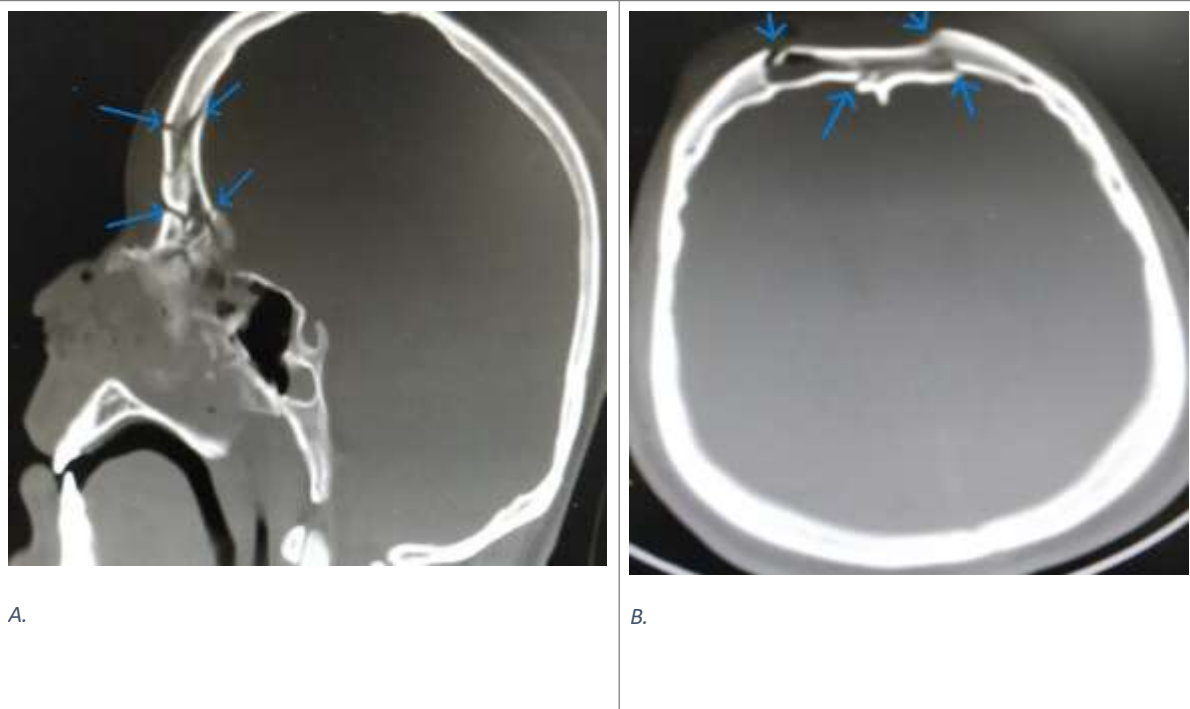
A.B. Sagittal and axial HRCT in a patient of CSF rhinorrhea showing fracture of the outer and inner table of frontal sinus (blue arrows) and ACF base fracture.
